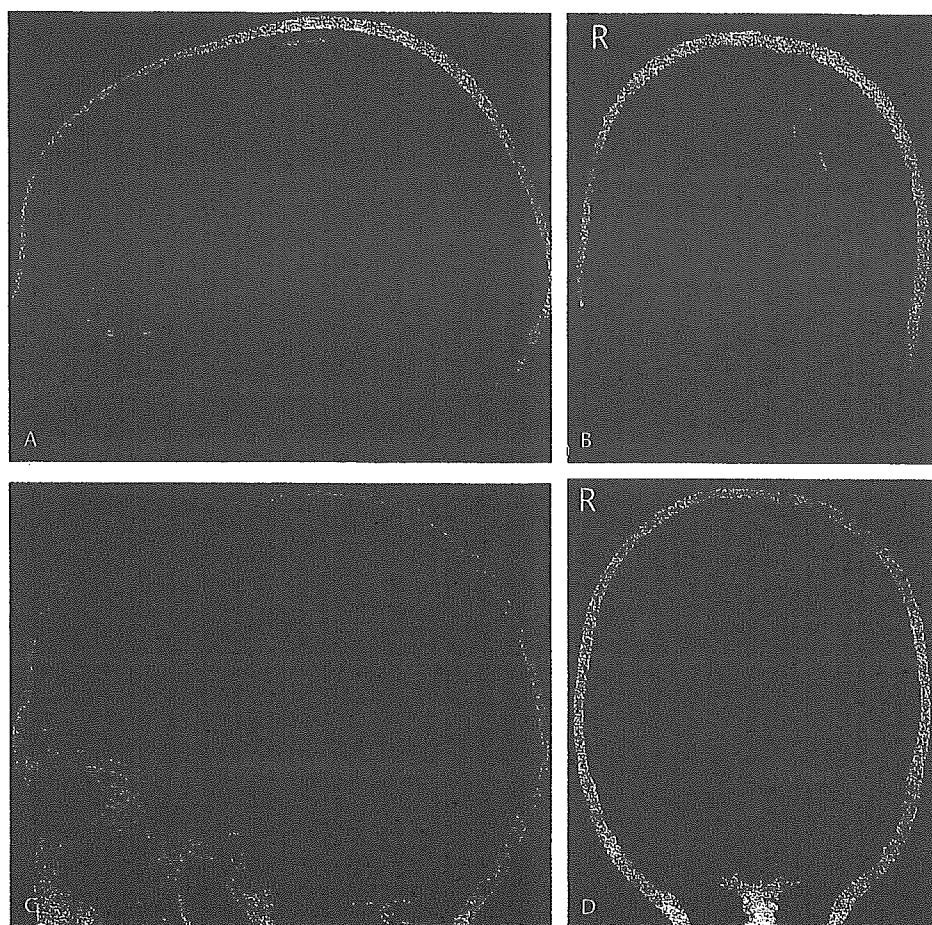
A, B, Sagittal and coronal T1-weighted MRI scan showed a high-density lesion on the left occipital lobe. C, D, Sagittal and coronal T1-weighted MRI scan became normal after chemotherapy.
